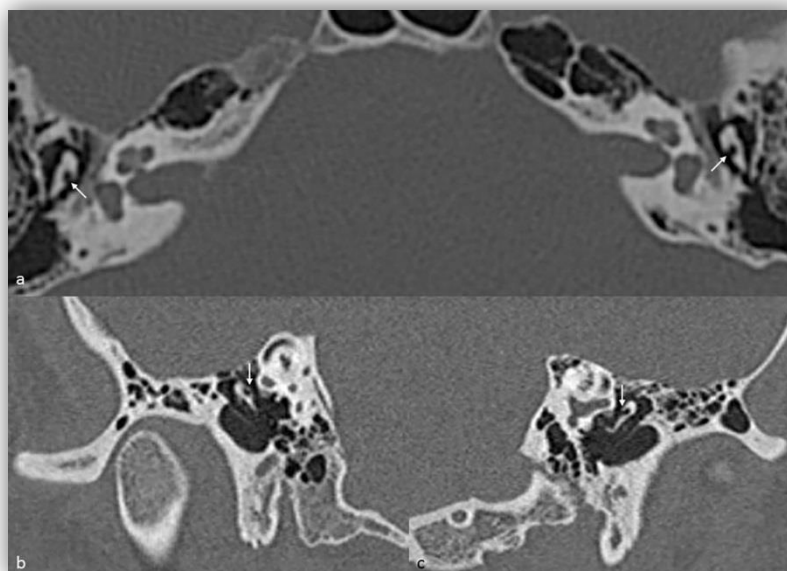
Axial (a) and coronal oblique (b and c) reconstructed high-resolution computed tomographic images showing bilateral cleft formation in the incus body (arrows).
